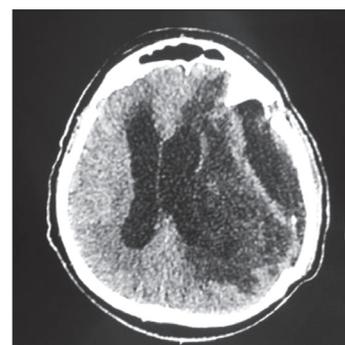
CT scan showing dilatation of the ventricles with periventricular oozing, signs of cyst re-expansion, and crowding of the gyri at the vertex, with small sulci
